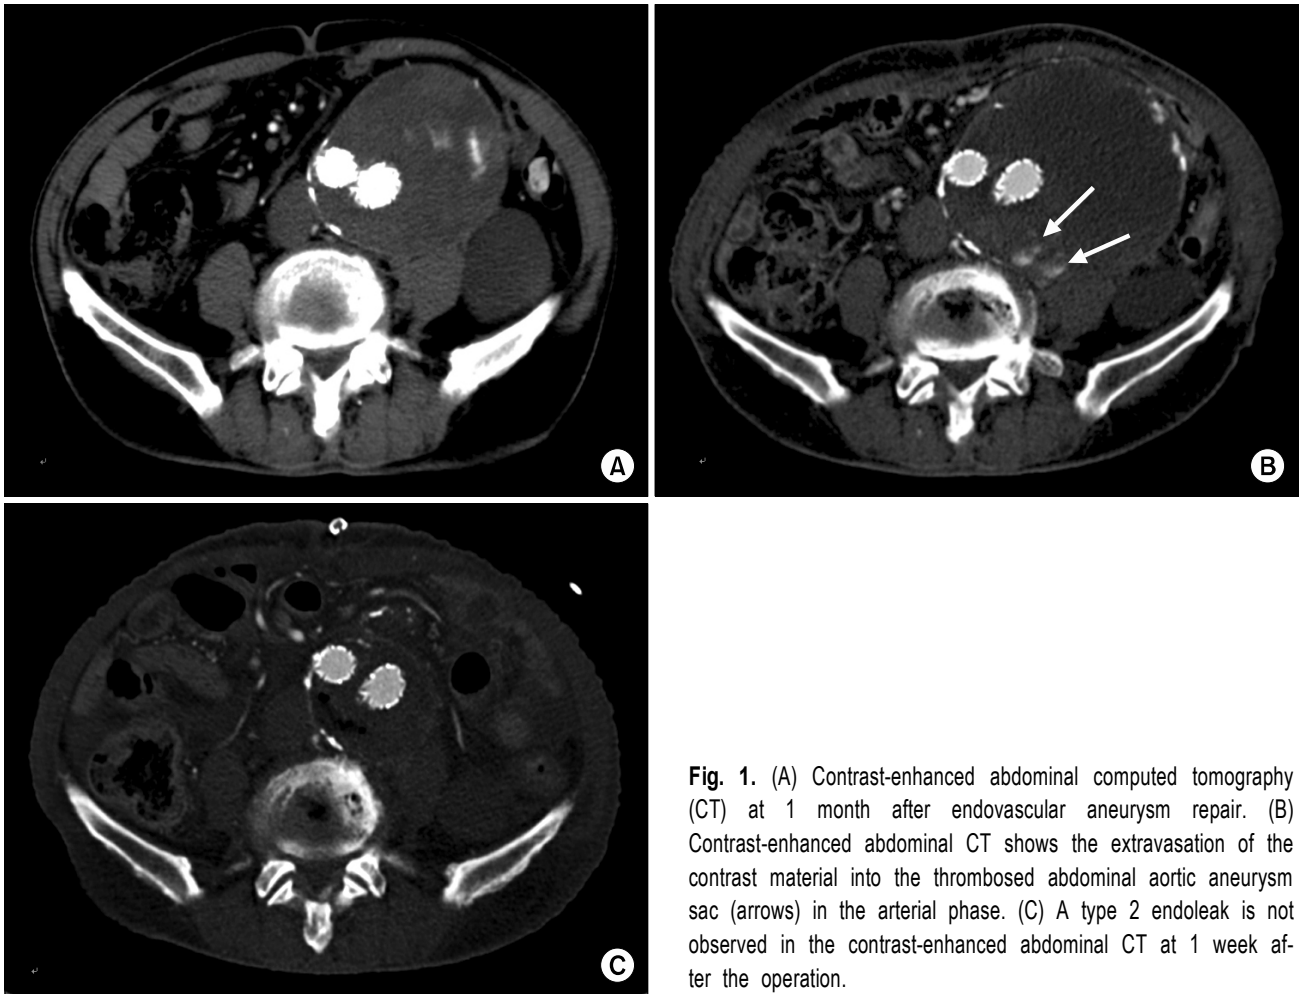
(A) Contrast-enhanced abdominal computed tomography (CT) at 1 month after endovascular aneurysm repair. (B) Contrast-enhanced abdominal CT shows the extravasation of the contrast material into the thrombosed abdominal aortic aneurysm sac (arrows) in the arterial phase. (C) A type 2 endoleak is not observed in the contrast-enhanced abdominal CT at 1 week after the operation.
